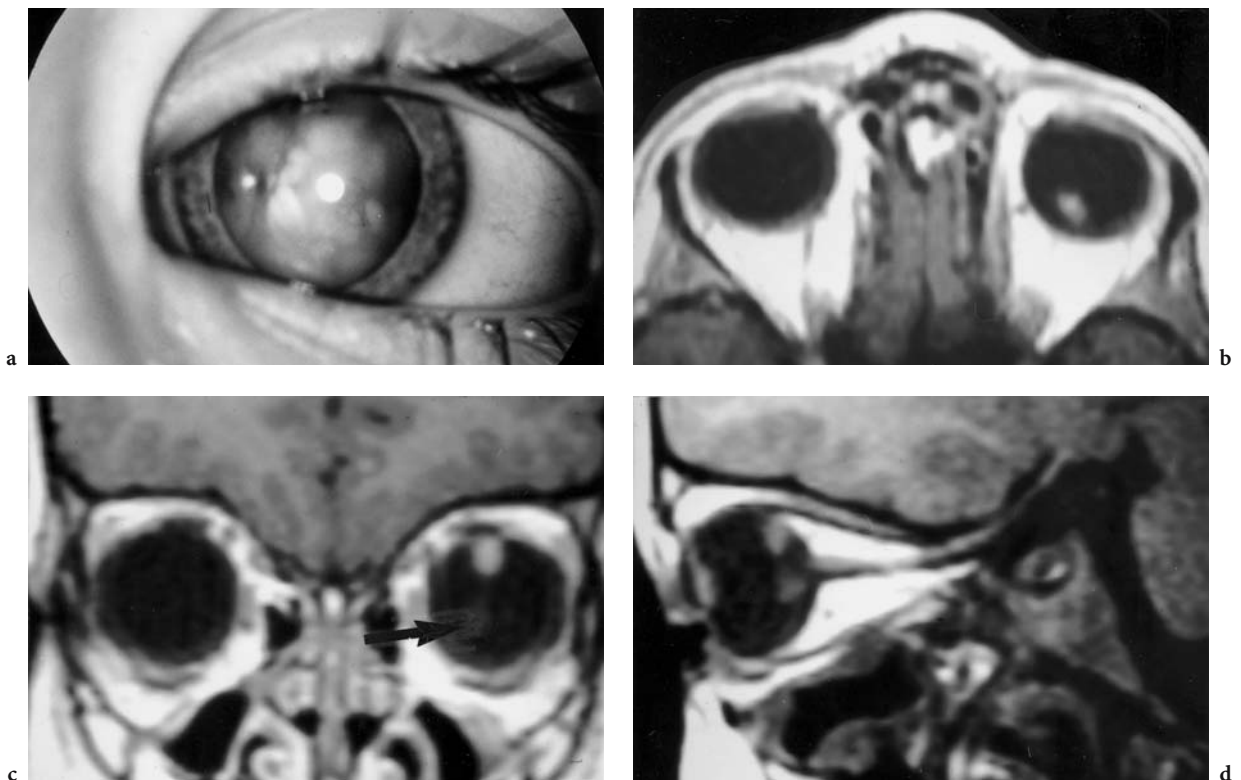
A 4-year-old boy with leukokoria of the left eye. Diagnosis: retinoblastoma. a View of the left eye, demonstrating leukokoria. b Axial T1-weighted, contrast-enhanced view with a small mass in the superior vitreous body. c Coronal T1-weighted, contrast-enhanced view shows the known drop-shaped tumor as well as a shadow at the center of the vitreous body (*arrow*), giving rise to the suspicion of a second lesion. d Sagittal paramedian contrast-enhanced, T1-weighted image, depicting two tumors located superior and inferior to the cribriform plate, respectively
